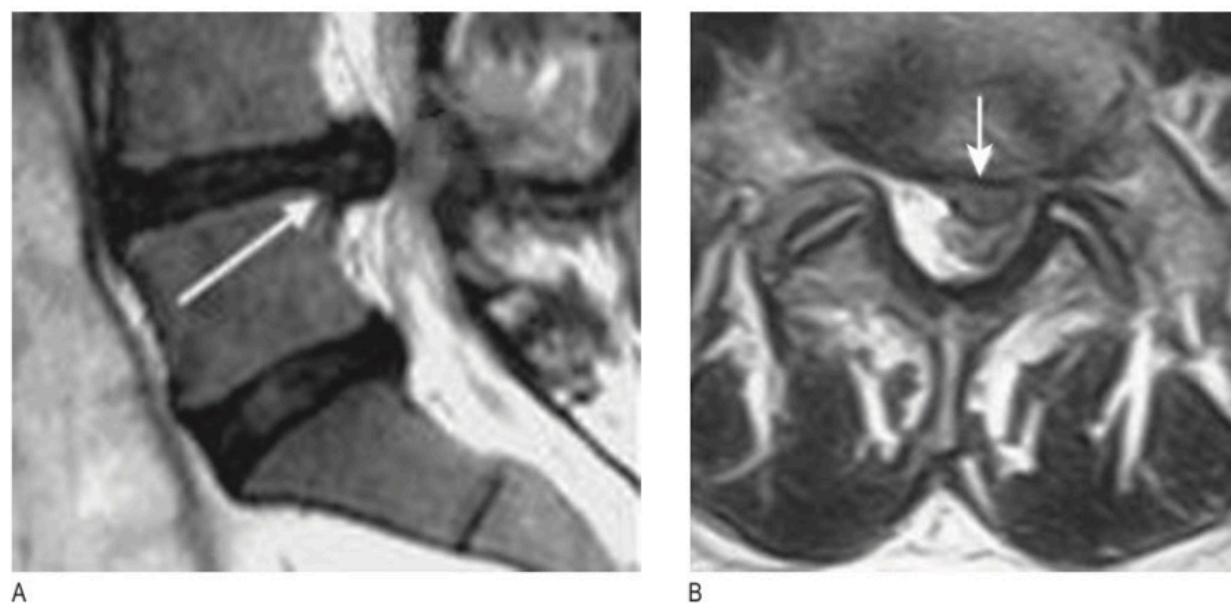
T2 magnetic resonance images showing a large left paracentral L4-5 disc protrusion (arrowed) compressing the L5 nerve root. A Sagittal section. B Axial section.
